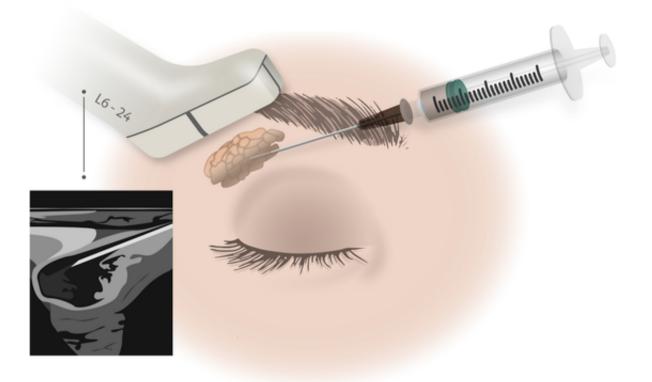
Injection into the lacrimal gland using ultrasonic guidance.
